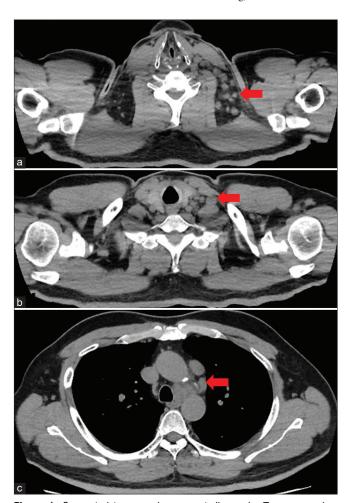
Computed tomography scan at diagnosis. Transverse view showed lymphadenopathies in the left neck at Levels IV and V (a), left supraclavicular fossa (b), and mediastinum (c)
